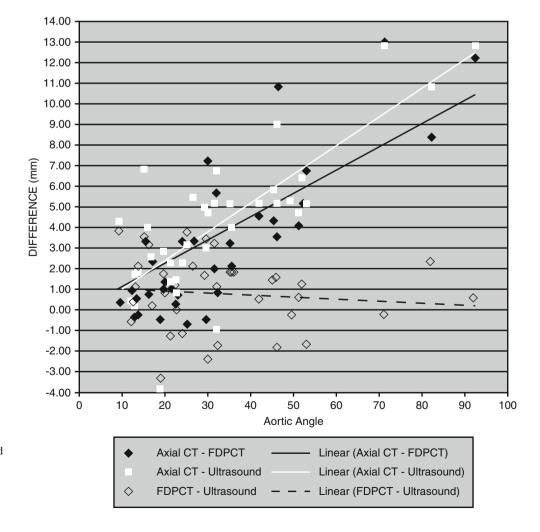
CT diameter (*black line*) versus ultrasound diameter (*dotted line*) in the same patients (Adapted from Sprouse et al. [31]. With permission from Elsevier)
